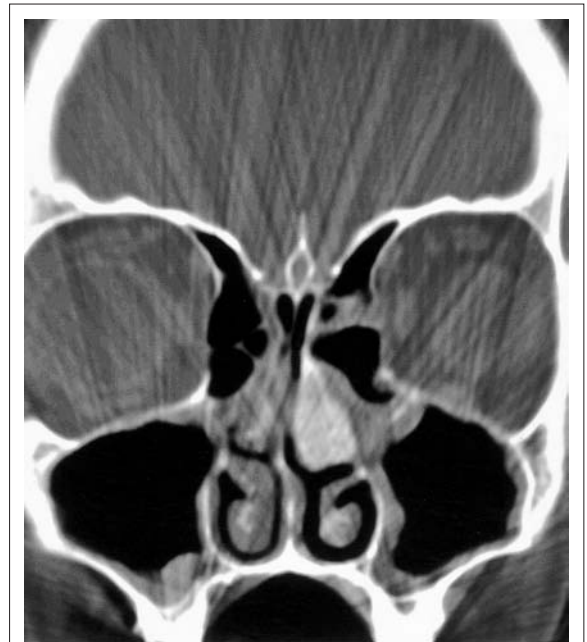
Coronal preoperative CT: enlargement of left middle turbinate with characteristic "ground-glass" appearance.
